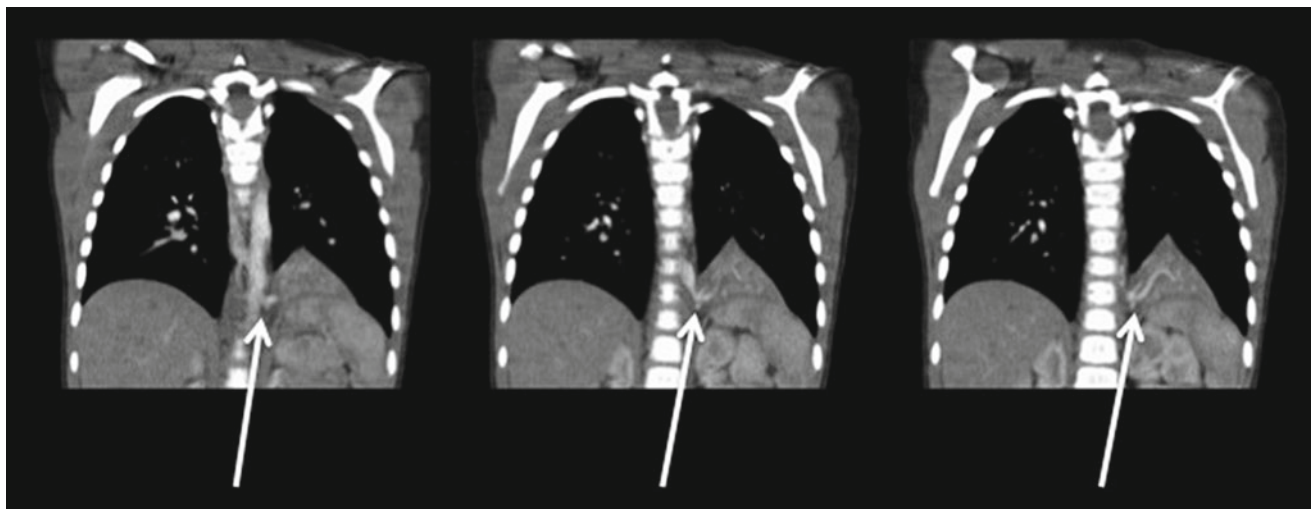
Sequential images from the chest CT of the patient referred to in Fig. 39.6. The *arrows* show the course of the aberrant artery arising from the descending aorta
